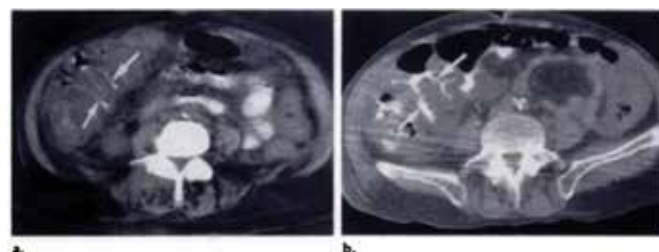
CT of Pseudomembranous colitis
